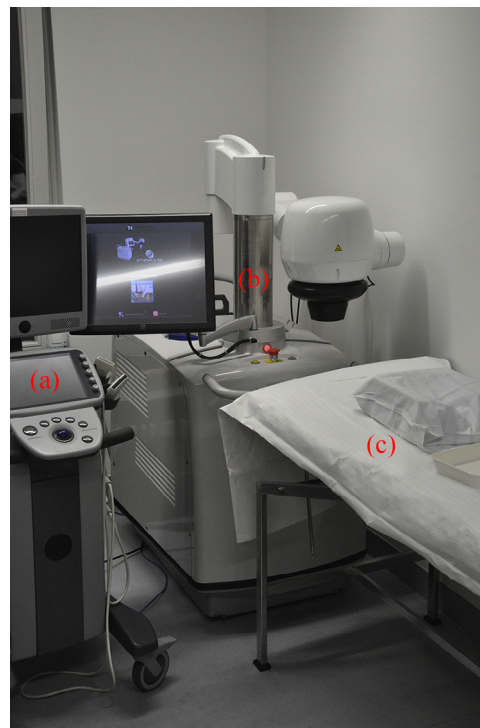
This figure shows the operative setting: (a) A separate ultrasound (US) system used to confidently identify the intended nodule. (b) The high-intensity focused ultrasound (HIFU) system used in this study (Echopulse THC900888-H, THERACLION SA, Malakoff—France). (c) A regular treatment couch with a head-shaped pillow to support the patients' head while hyperextending their neck.
